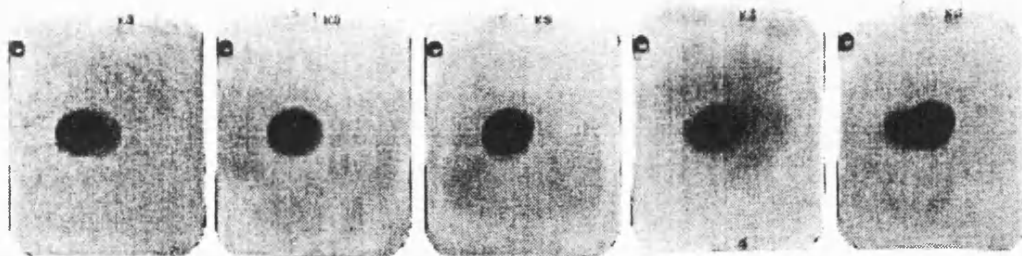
Stack of dental x-ray films exposed at position of critical volume on CSD apparatus. Films show intersection of beam spots from x-ray tubes A and B.
